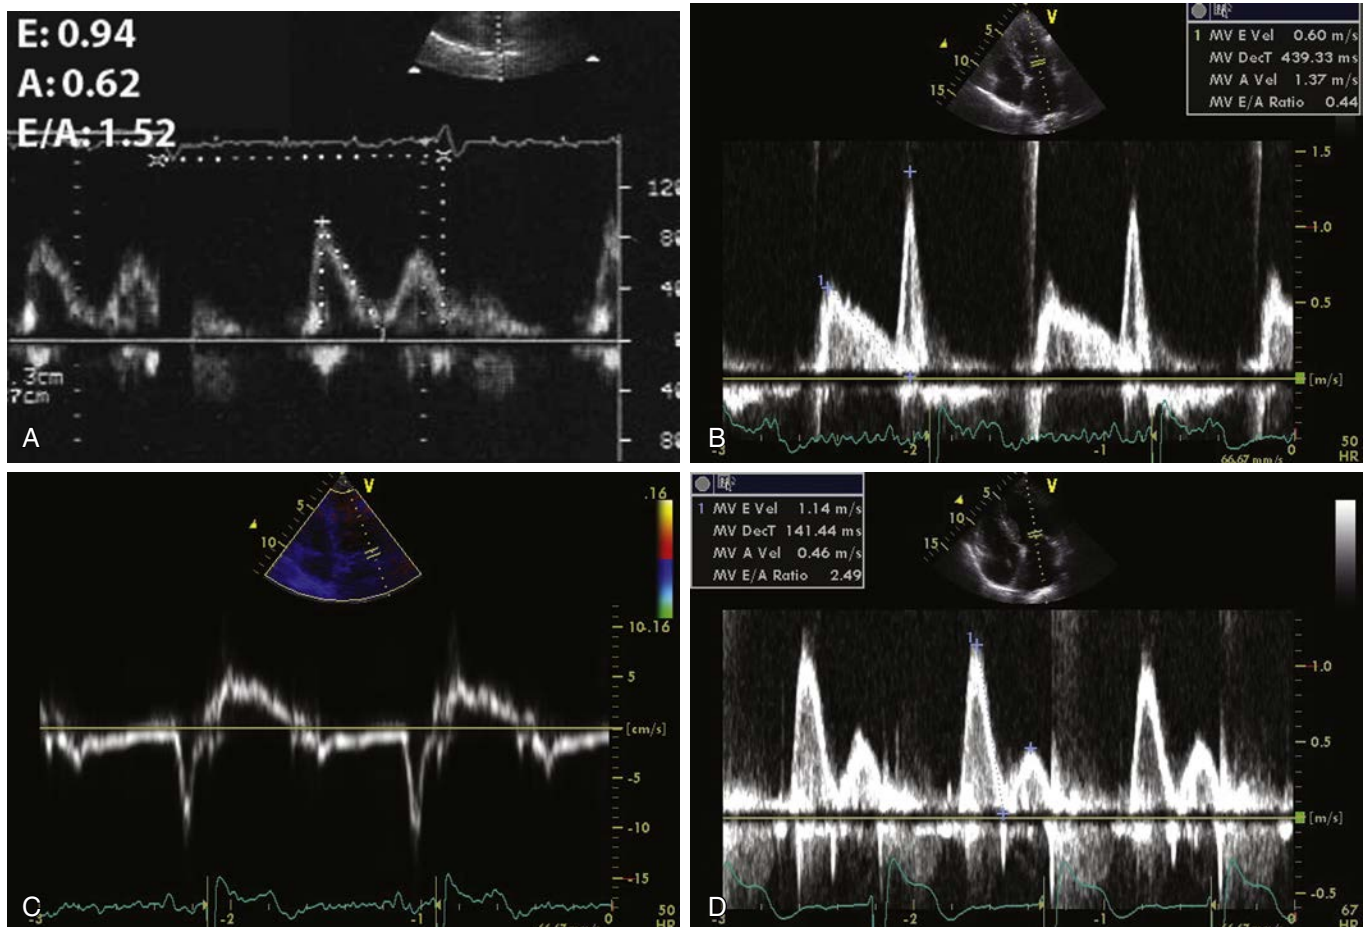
Evaluation of left ventricular (LV) diastolic dysfunction (see also Table 31-1). (A) Example of a normal pulsed-wave Doppler mitral valve (MV) profile: E wave is 94 cm/sec, deceleration time (DecT) is 174 msec, and E/A ratio is 1.52. (B) Mitral flow velocity recording shows abnormal relaxation: E/A ratio is 0.44, and DecT is prolonged (439 msec). (C) Pseudonormal pattern: Myocardial tissue Doppler imaging (TDI) of the mitral annulus at the lateral level depicts inversion of the normal pattern, with E_m less than A_m . (D) Restrictive MV flow pattern with short DecT (141 msec) and E/A of 2.5.
